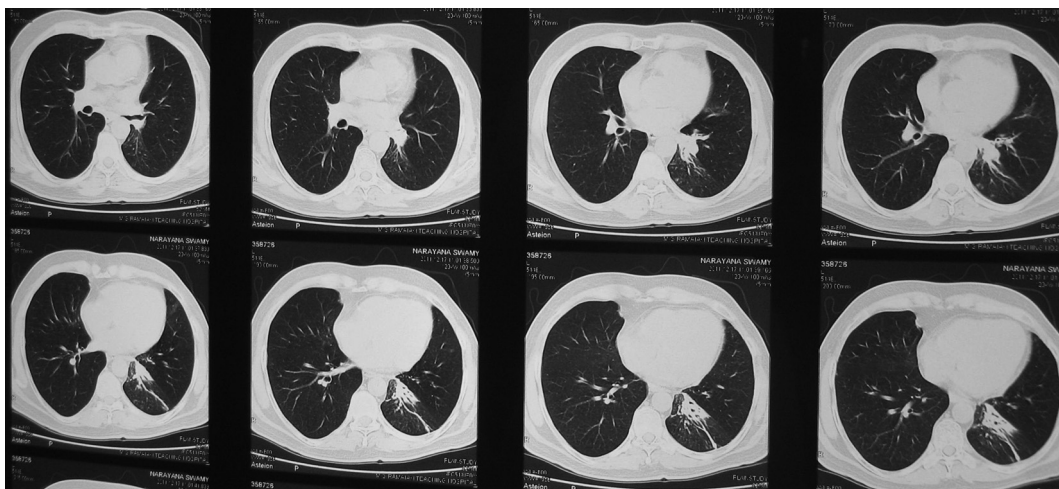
CT Thorax post-treatment showing reduction in the peribronchial lesion.
